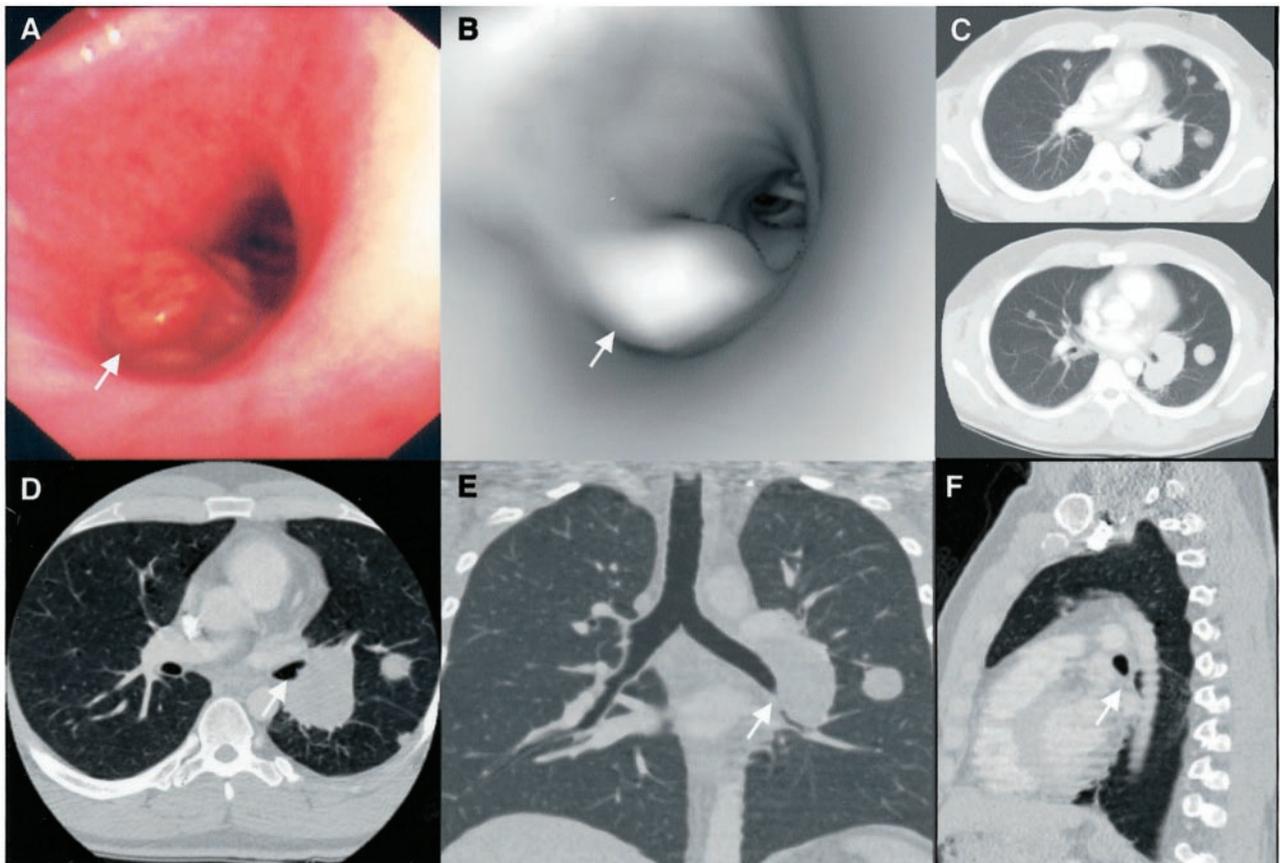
Endoluminal lesion obstructing the superior segment of the left lower lobe in a 30-year-old gentleman in whom metastatic melanoma has been diagnosed. The visualization of this lesion (white arrow) took place by FB (*top left*, A), VB (*top middle*, B), and SHR-CT scan (*bottom left*, D: axial section; *bottom middle*, E: coronal section; and *bottom right*, F: sagittal section). However, this lesion was not seen by consecutive conventional CT sections (*top right*, C).
